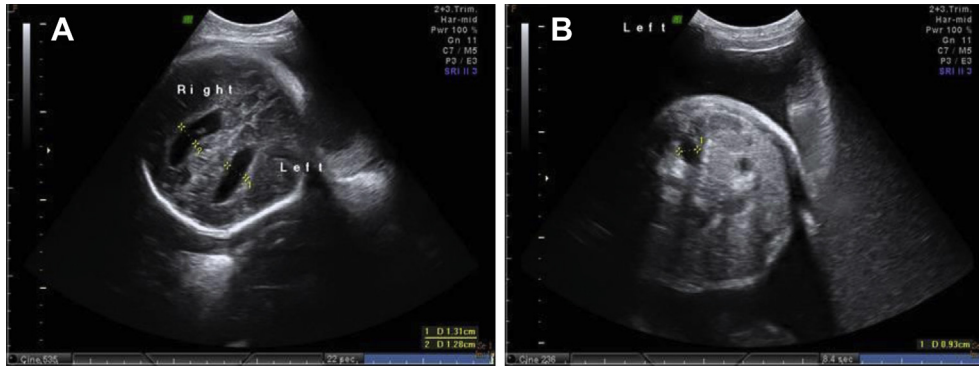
Prenatal ultrasound at 35 weeks of gestation shows (A) ventriculomegaly and (B) left pyelectasis.
